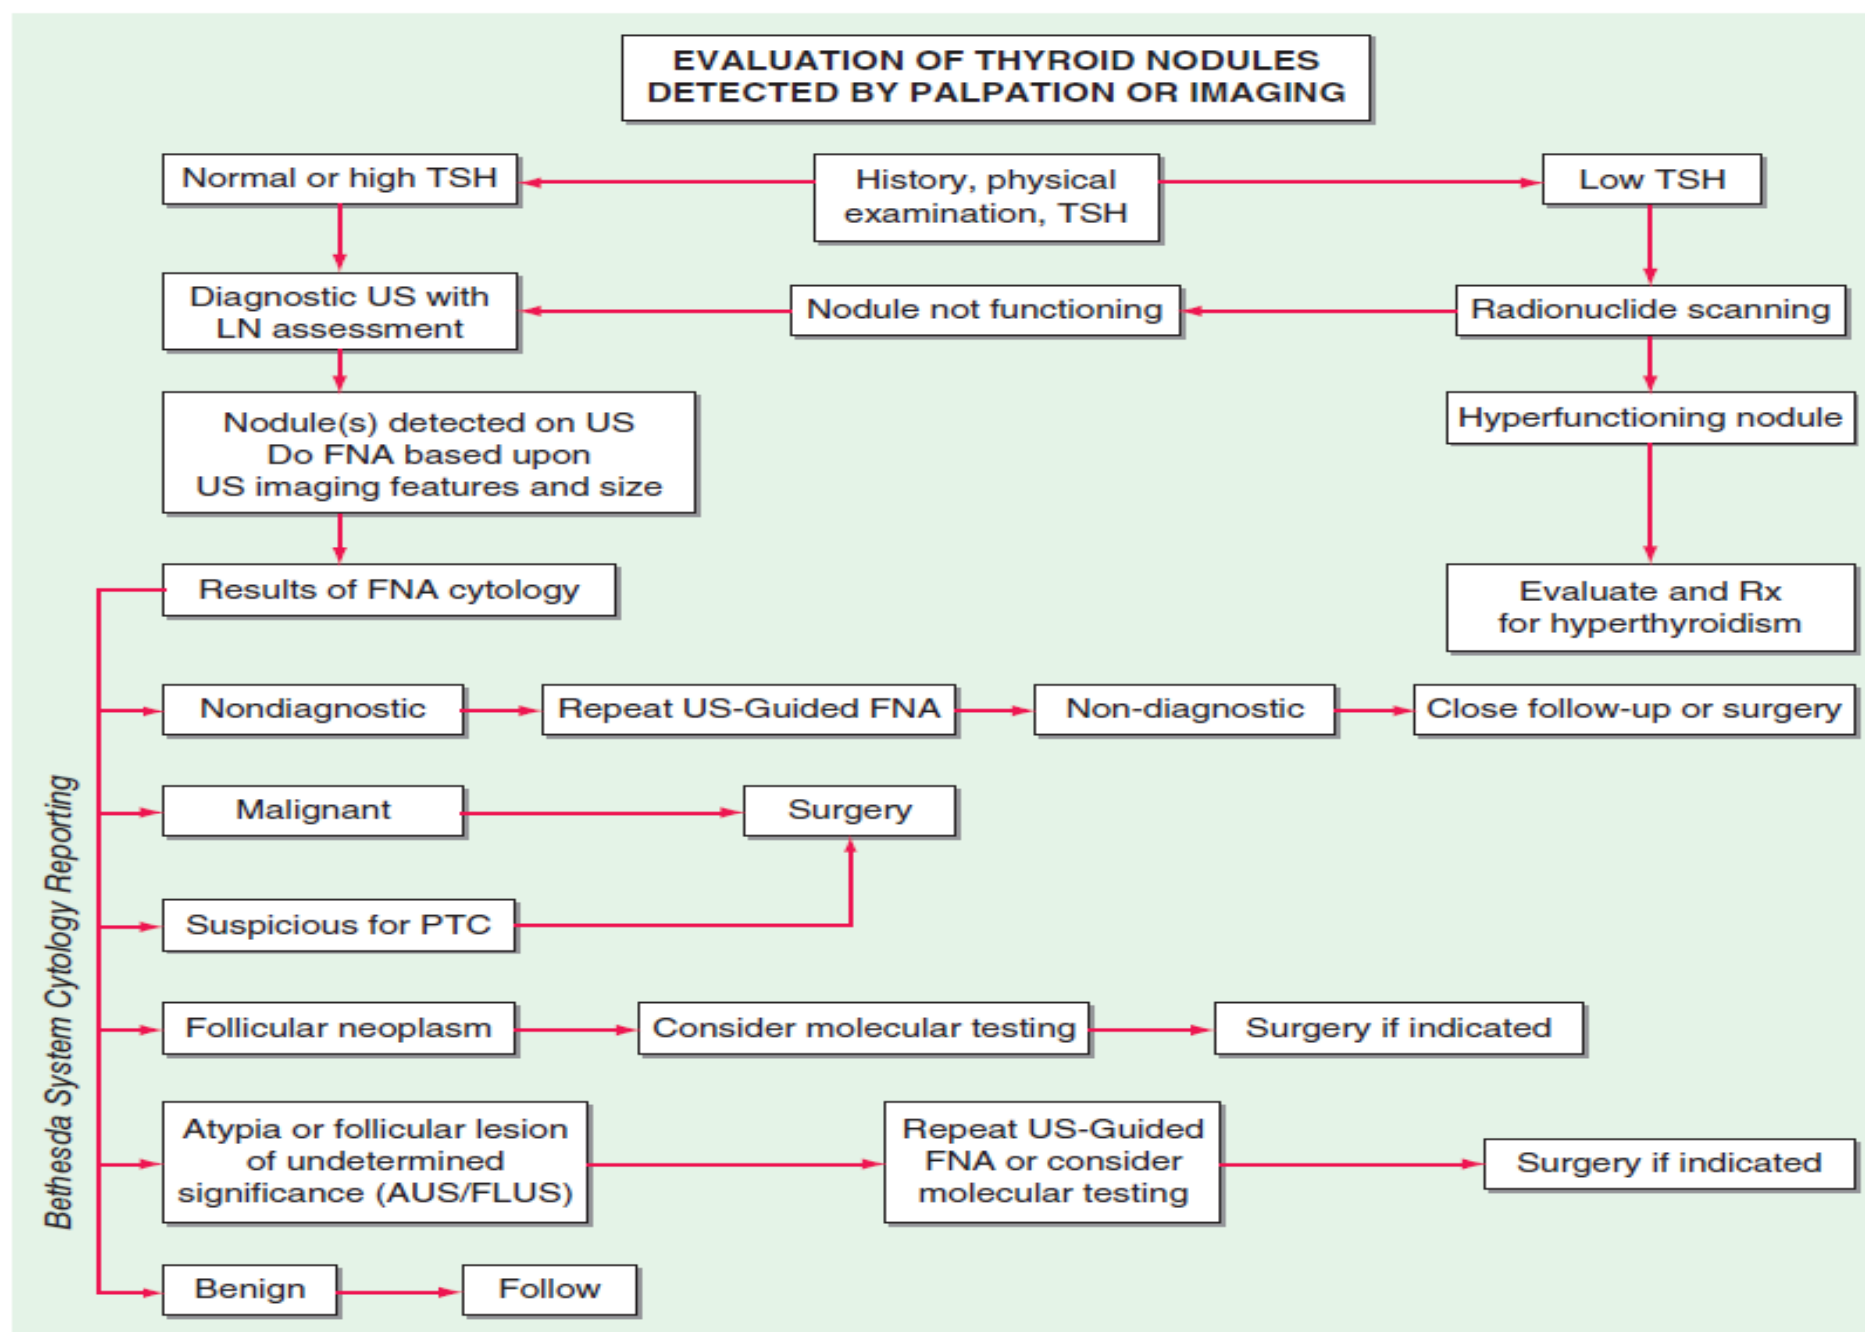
Approach to the patient with a thyroid nodule. See text and references for details. FNA, fine-needle aspiration; LN, lymph node; PTC, papillary thyroid cancer; TSH, thyroid-stimulating hormone; US, ultrasound.
